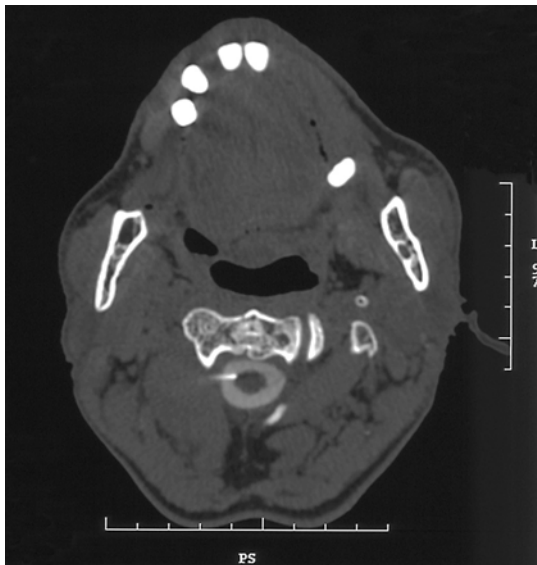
Final position of the cannula on axial CT scan at the C1–2 level in percutaneous cordotomy
